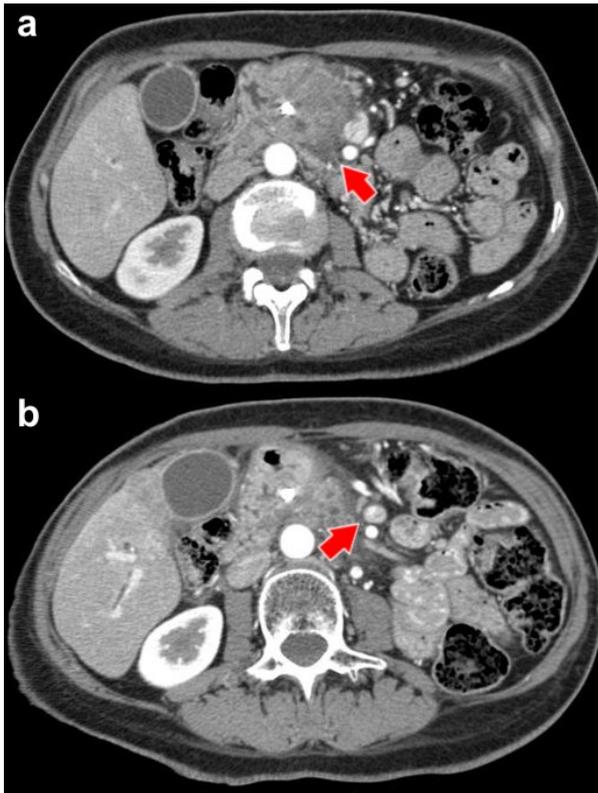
CT scans of abdomen at the level of pancreatic lesion. a. A pancreatic head mass measuring 4.5x3.2 cm with inflammatory changes or neoplastic extension adjacent to the posterior head and along the right border of the superior mesenteric artery is noted (arrow). b. Post neoadjuvant chemoradiation therapy with intratumoral TNFerade™ administration. Decreased perfusion is noted. The tumor has reduced size (3.1x3.3 cm) and importantly the prior change along the superior mesenteric artery border is improved (arrow).
